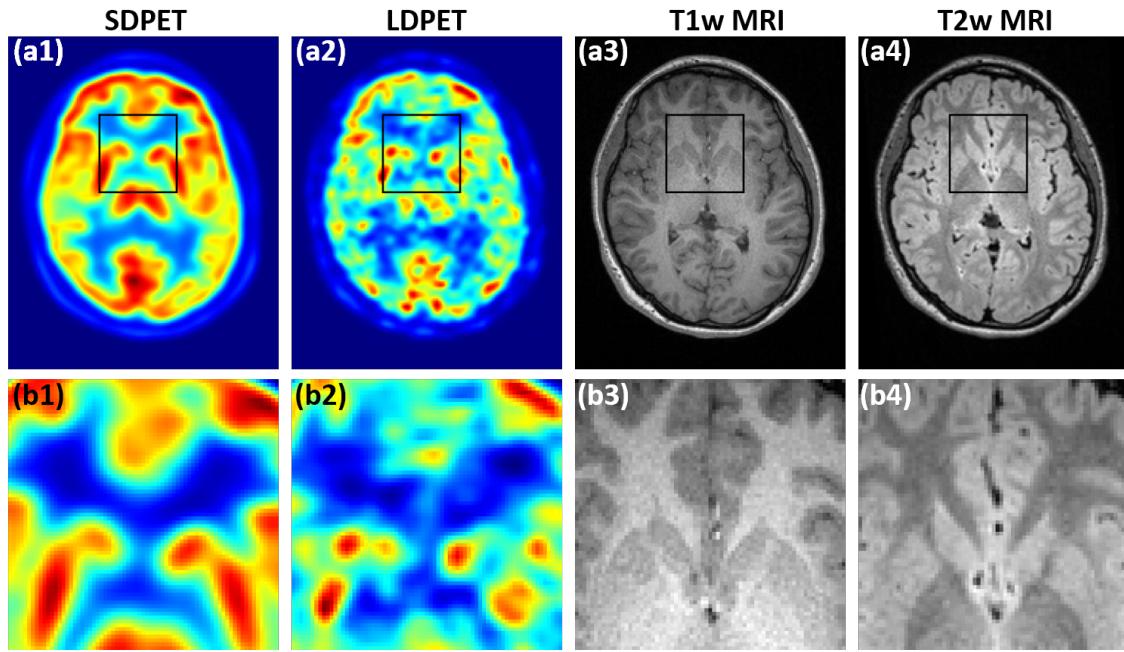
Visualization of low-dose and standard-dose FDG-PET images along with corresponding T1w and T2w MRI images. Top: (a1):standard-dose PET image (SDPET); (a2):low-dose PET image (LDPET) at DRF = 180 $\times$ ; (a3) and (a4): T1w and T2w MRI images; Bottom: (b1)–(b4): corresponding zoomed region of interest. The zoomed region of interest is highlighted using the black rectangle box in (a1)–(a4).
